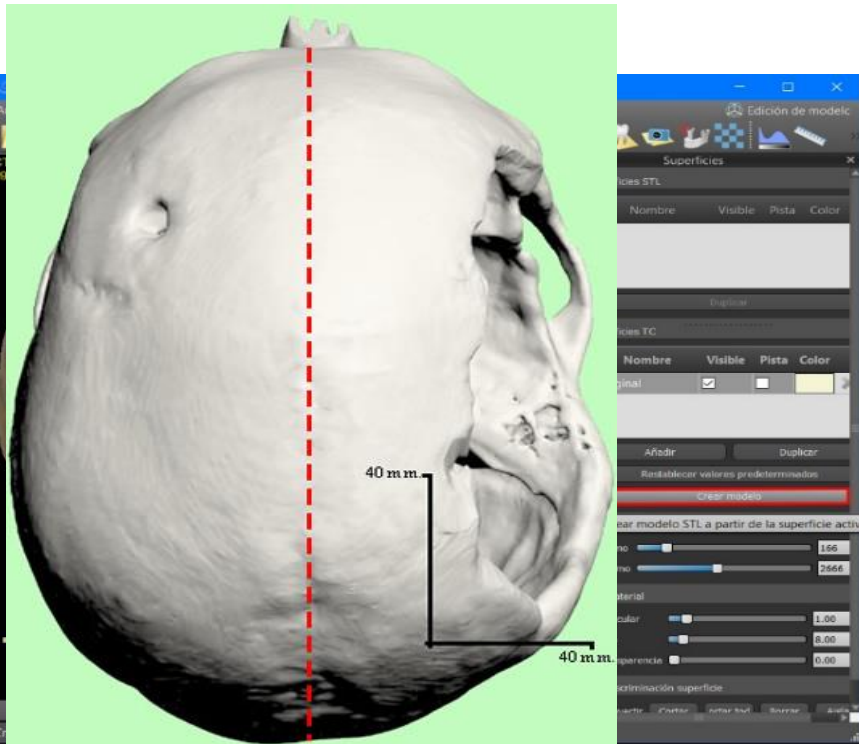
Display of the CT Scan of the patient in the Blue Sky Plan 4 software. The left side depicts a healthy skull, and the right side shows the surgical site. The figure was generated in Blue Sky Plan 4.
